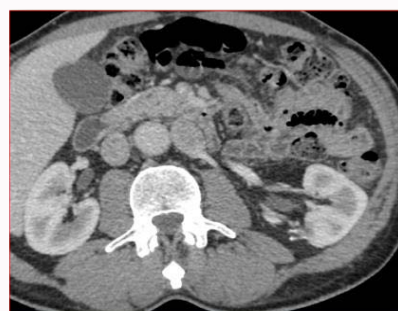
A CT image. Post-surgical changes on the left kidney with no signs of recurrence can be appreciated.
